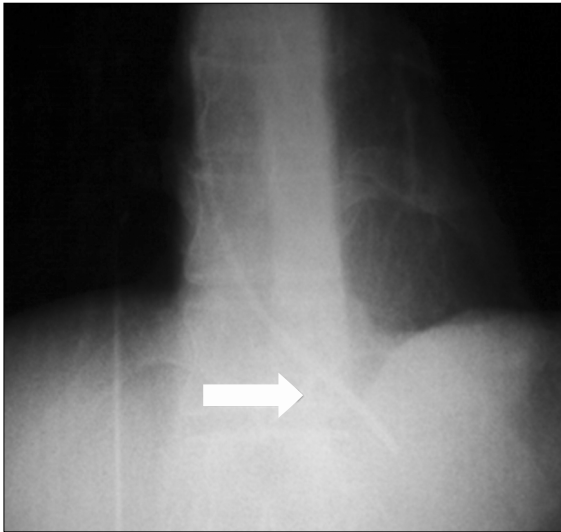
Part of a fractured catheter that had migrated to the right ventricle (X-ray imaging, arrow).
